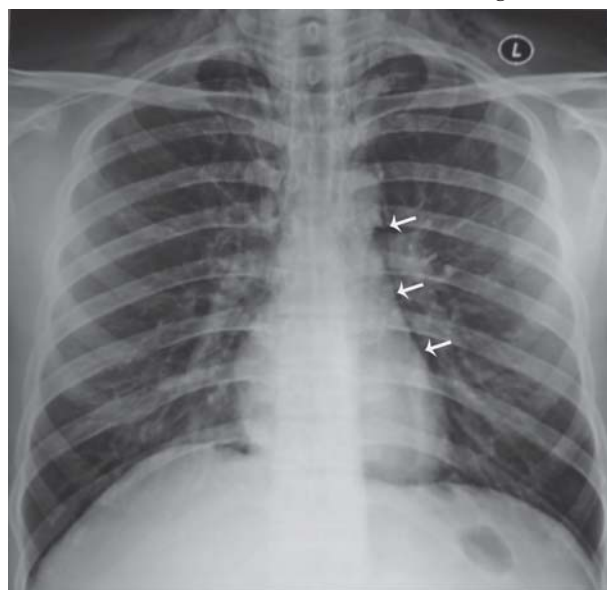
Chest radiograph (postero-anterior view) showing spontaneous pneumomediastinum (three arrows).
